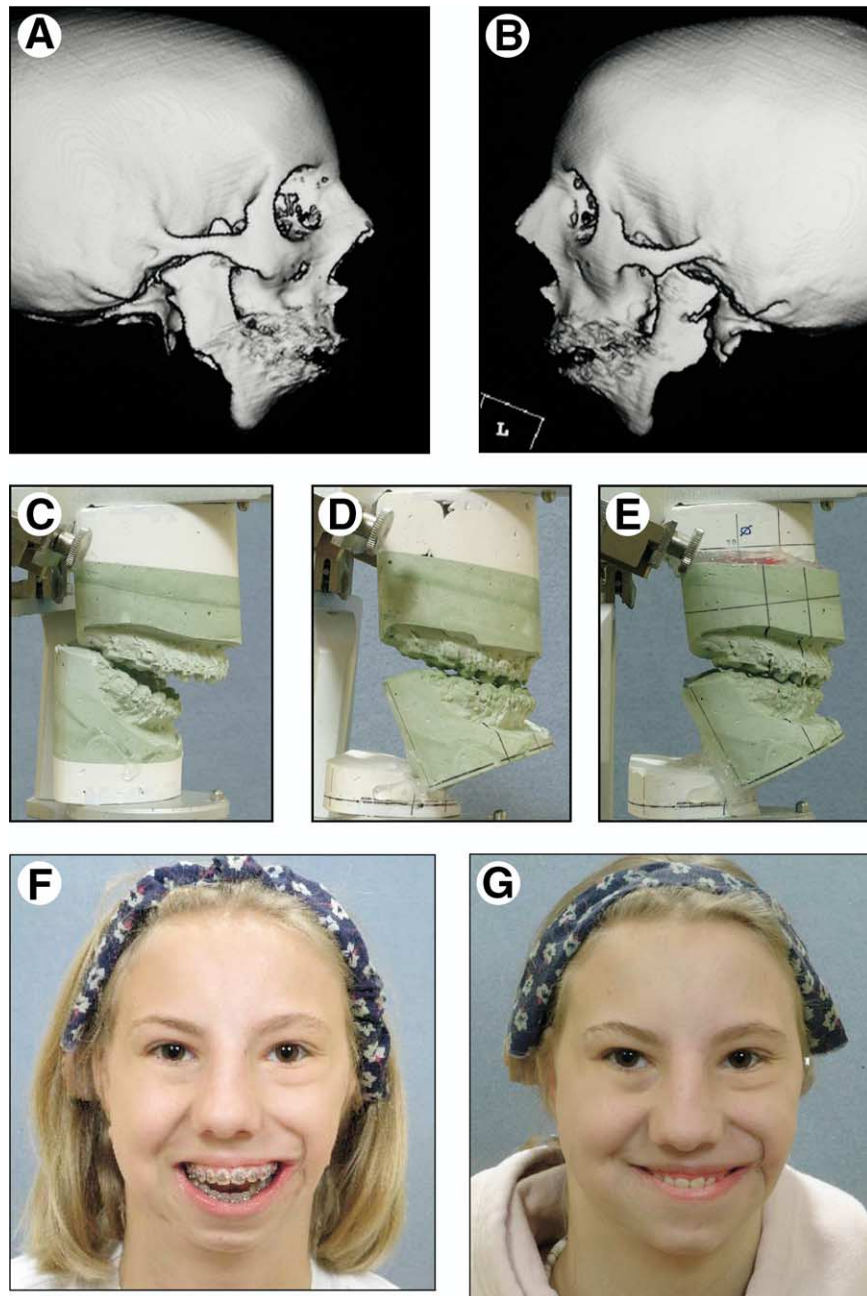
A female was born with an asymmetric bilateral form of hemifacial microsomia. At 16 years of age, she underwent a maxillary Le Fort I osteotomy, bilateral coronoidectomies, bilateral sagittal ramus osteotomies with autogenous iliac corticocancellous interpositional bone grafts, and an oblique osteotomy of the chin. A, B, Lateral craniofacial CT scan views before reconstruction. C–E, Articulated dental models demonstrating stages of reverse model surgery planning. F, G, Frontal smile views before and after reconstruction. (Figure 3 continued on next page.)
